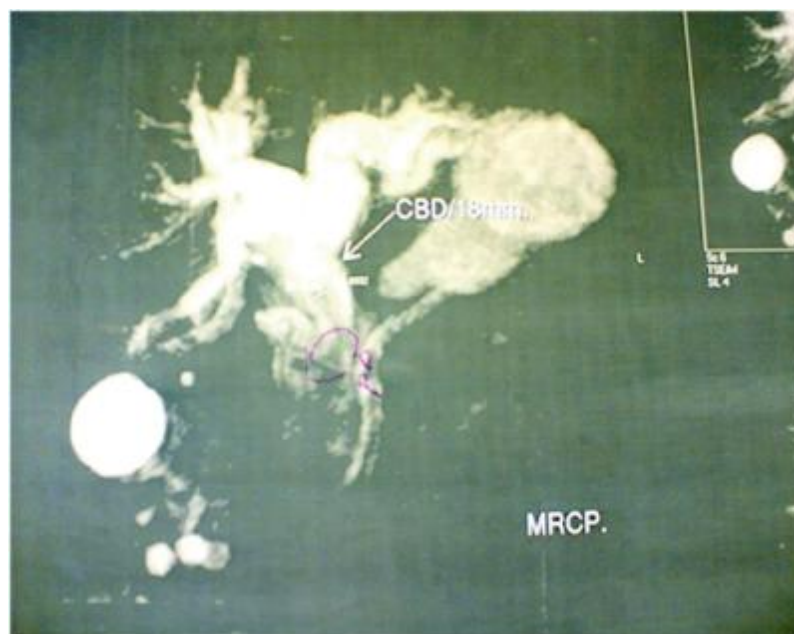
MRI of liver&MRCP with Left lobe hydatid cyst and left Intrabiliary rupture
